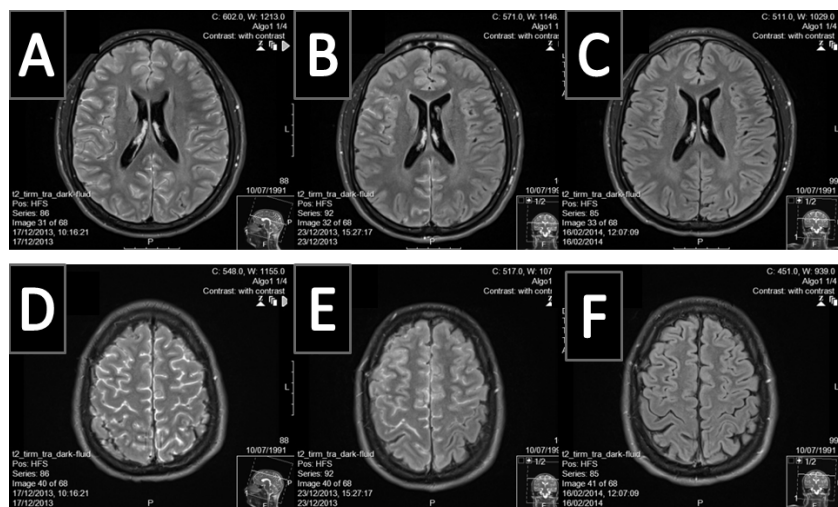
FLAIR post gadolinium images on presentation (A,D) show massive diffuse hyperintensity in CSF spaces which represent enhancement of the meninges. Notice no focal lesions, gray matter or white matter changes observed. One week later after 4 HBOT sessions (B,E) images show decreased enhancement of the meninges. One month after presentation and total of 14 HBOT sessions, the images (C,F) show normal brain MRI.
